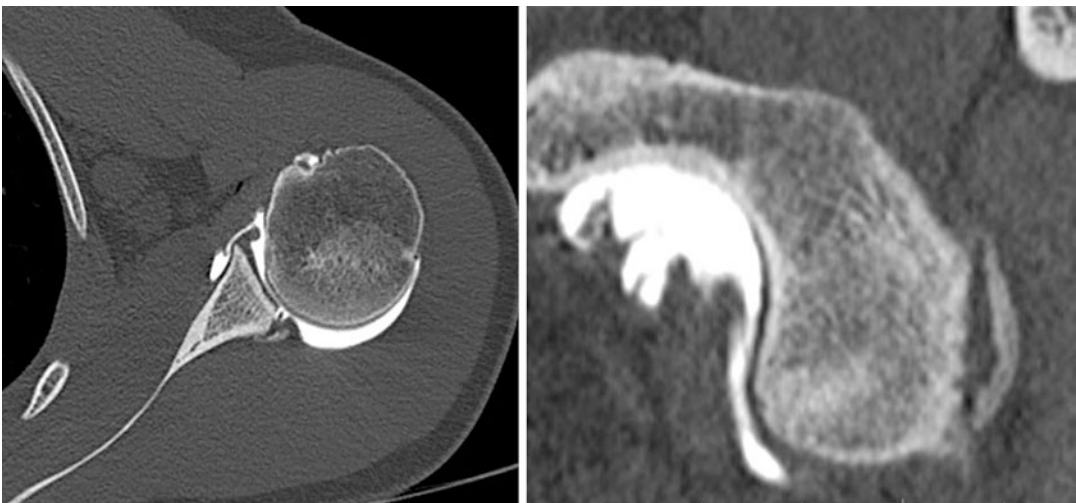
Computed tomography of a patient with posterior bony Bankart lesion. In this patient, the conservative treatment for posterior instability failed
